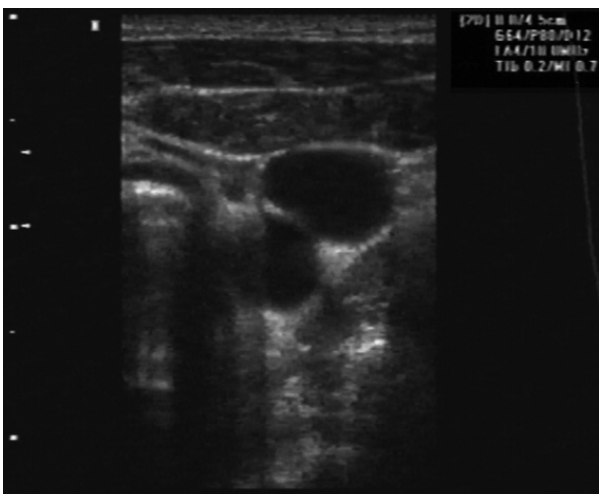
Sonographic view along the short axis of the right internal jugular vein and carotid artery. These structures appear normal.
